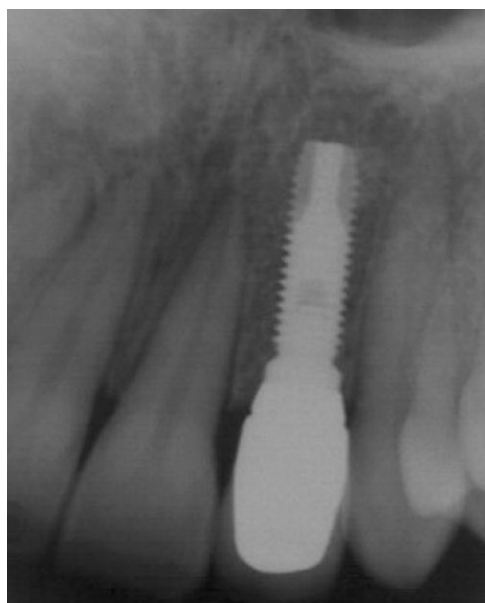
Follow-up radiograph at 42 months.
